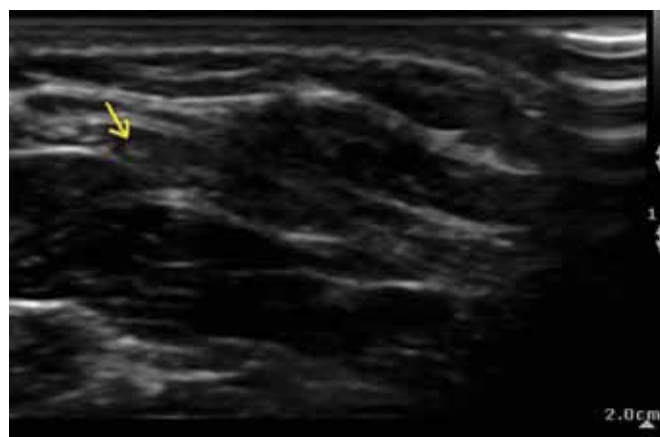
Ultrasound depiction of accessory cranial nerve on the posterior cervical triangle.
